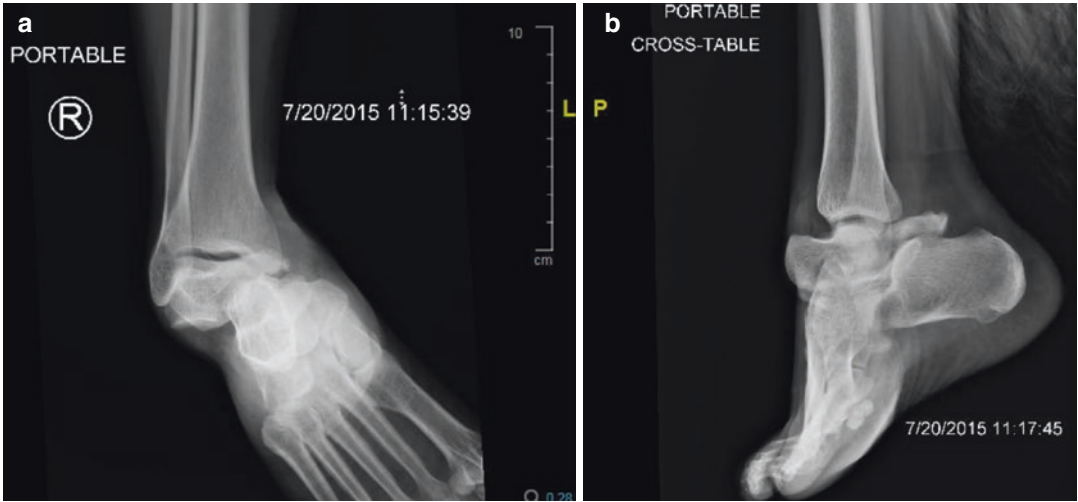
(a, b) Injury films for Case 1. “Presenting injury radiographs showing a posteromedial subtalar dislocation with associated talus body fracture”
